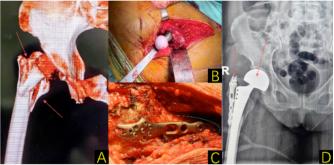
(A) Three-dimensional reconstructions indicated the presence of a right intertrochanteric fracture with associated peritrochanteric involvement and displaced fractures. (B) The femoral stem was implanted first, followed by the insertion of the femoral head. (C) A proximal femoral locking plate was used. (D) Follow-up x-rays confirmed that the surgical hardware was appropriately positioned.
